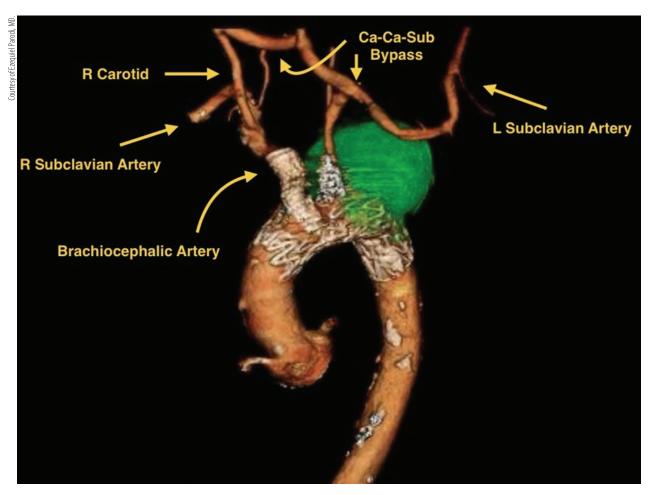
Postoperative CTA 3D reconstruction with labeled arch branches and endovascular and open arch debranching reconstructions.
